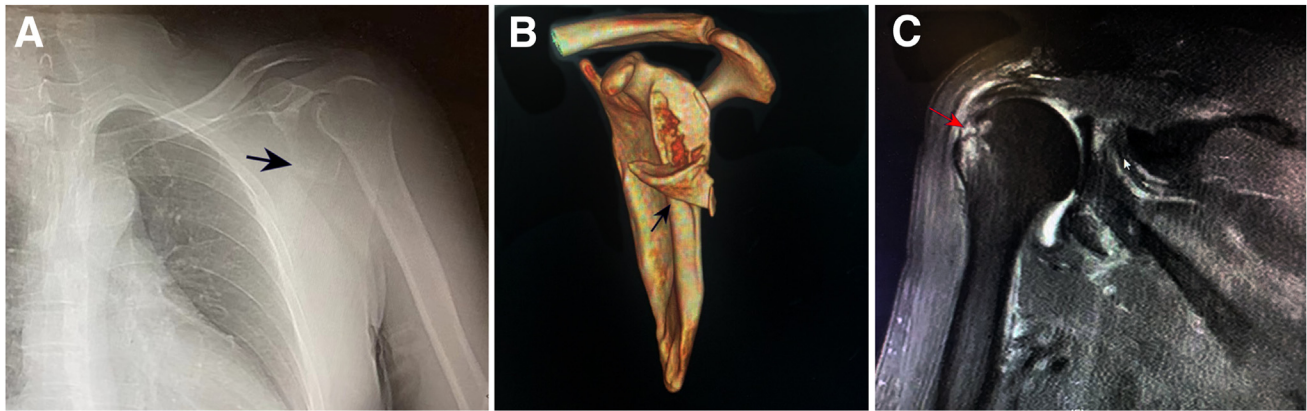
Results of imaging. 45-year old, male, Bony Bankart injury of left shoulder. (a) Anteroposterior radiograph shows a fracture of the glenoid (black arrow), with the humerus head located within the left shoulder joint. (b) Three-dimensional computed tomography (3D-CT) reveals significant displacement and rotation of a large fracture fragment (black arrow). (c) Magnetic resonance imaging (MRI) demonstrates edema and a fracture of the great tuberculum of the humerus, along with rotator cuff insertion injury (red arrow).
